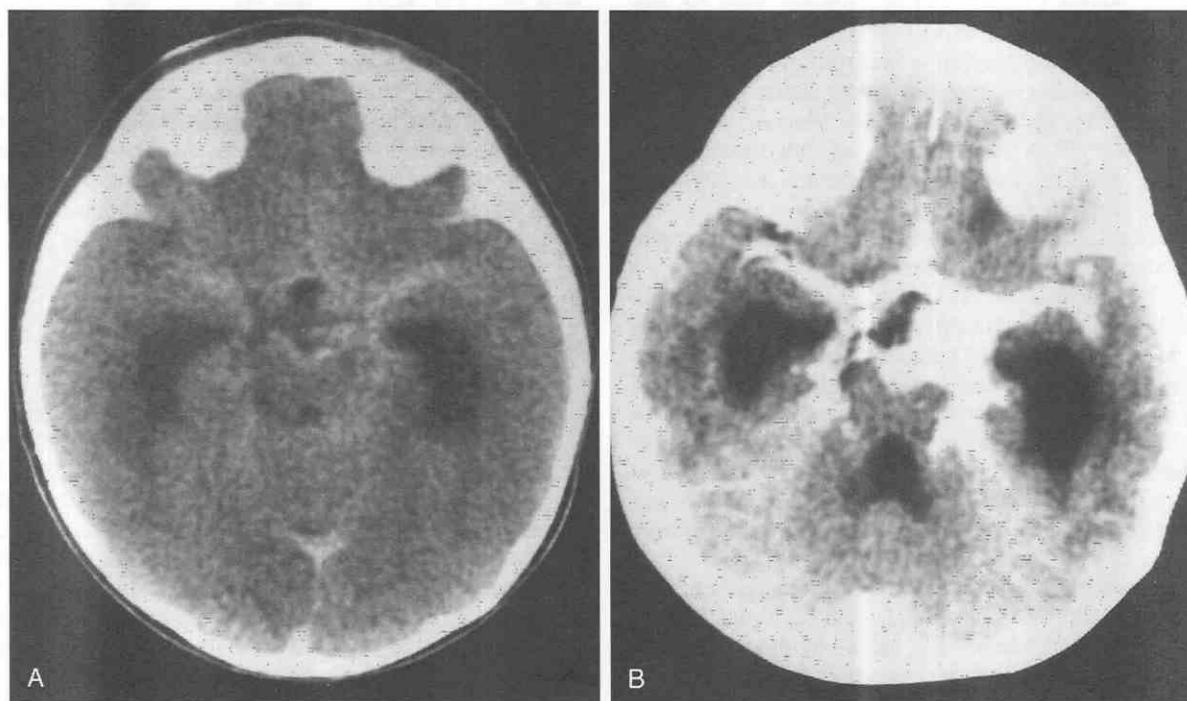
Tuberculous meningitis. *A*, Noncontrast CT scan shows high-density material in the suprasellar cistern, sylvian cistern, and perimesencephalic cistern. Dilation of both temporal horns is seen. *B*, Contrast CT scan shows diffuse intense enhancement in the involved cisterns.
